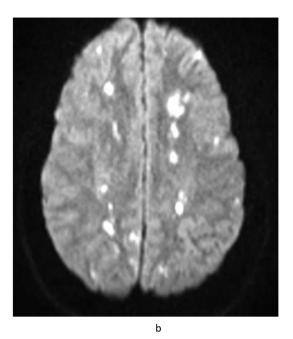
a & b. MRI Brain of case 2 showing multiple embolic infarcts.
